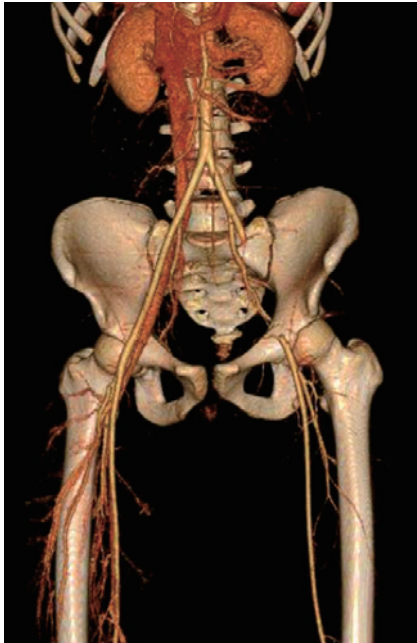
A 3-dimensional, contrast-enhanced computed tomography scan reveals a 120-mm-long vascular occlusion extending from the left external iliac artery to the left common femoral artery.
